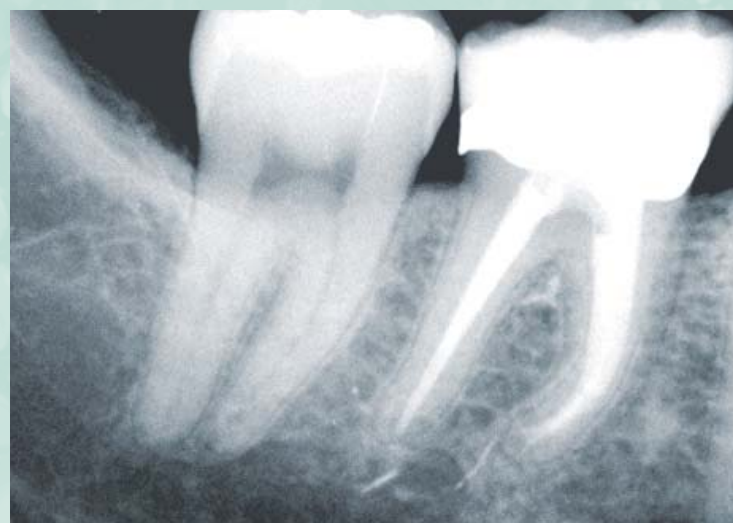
One-year recall radiograph shows normal periapex. Tooth was restored with bonded core and full-coverage crown and is asymptomatic.
